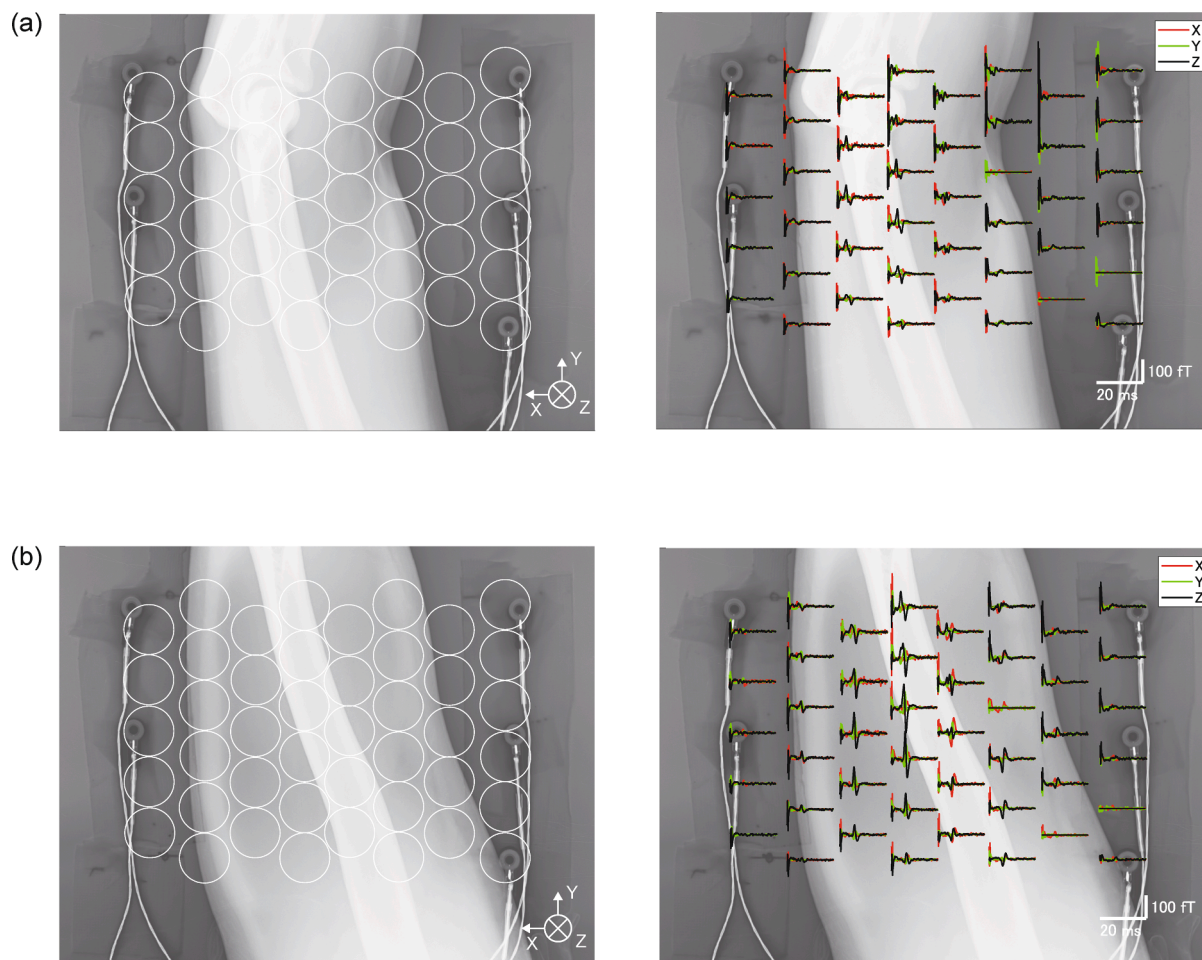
Evoked magnetic field of the representative case. Evoked magnetic field was recorded from each sensor and the radiograph. The white circles represent the sensor positions. The red waveforms represent the magnetic field recorded from the X-directional coils, with the X-axis positively upward. The green waveforms represent the magnetic field recorded from the Y-directional coils, with the Y-axis positively upward. The black waveforms represent the magnetic field recorded from the Z-directional coils, with the direction towards the floor being positively upward. The polarity was reversed on both sides of the presumed radial nerve.
